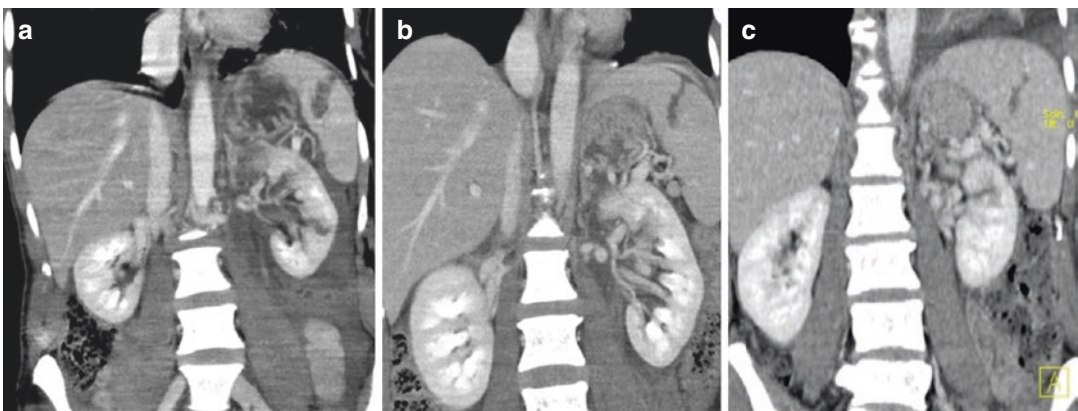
Example of a NOM follow-up: These coronal CT reconstructions show a spontaneous healing of a splenic parenchymal laceration (larger than 3 cm—
